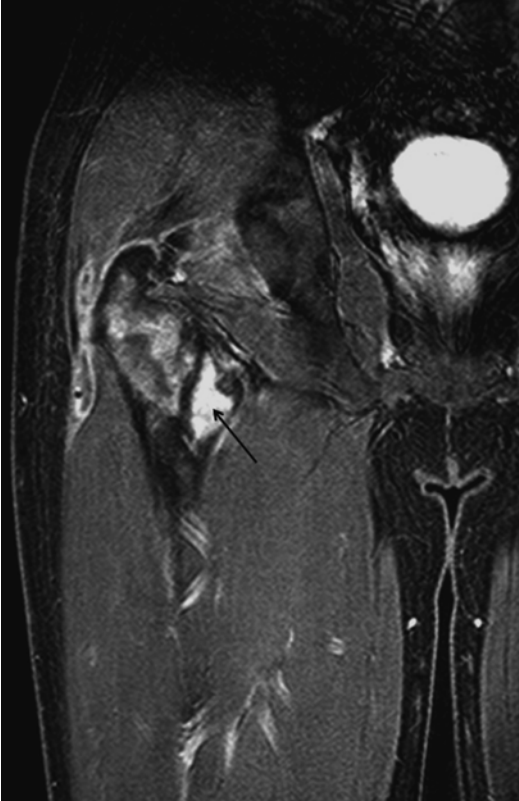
At the completion of chemotherapy, MRI of the hip revealed residual area of enhancement in the proximal right femur with a region of intense enhancement at the level of the lesser trochanter (*arrow*), highly suspicious of residual infiltrate
